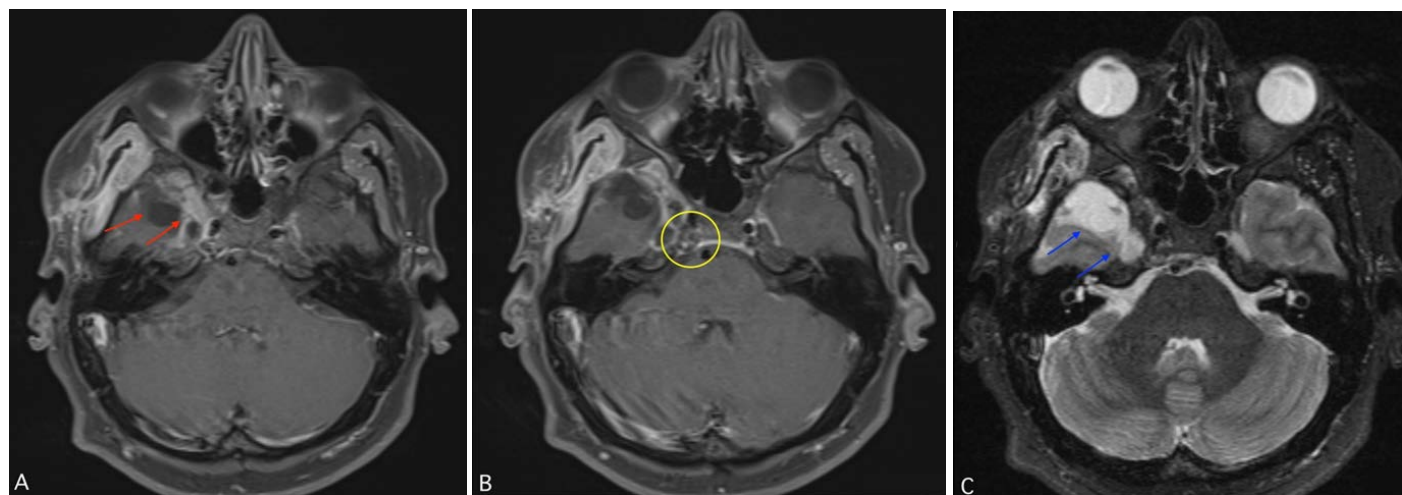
Postoperative MRI of the skull base. Axial T1 postcontrast (A, B) and axial T2 (C) images demonstrate postoperative changes of interval right pterional craniotomy for resection of the skull base chondrosarcoma. Lobulated area of homogenous enhancement within the medial floor of the right middle cranial fossa along the previously resected right sphenoid wing felt to represent postoperative changes (A) with corresponding T2 hyperintensity (blue arrows). Within the posterior aspect of the right petroclival junction (yellow circle), there is a focus of heterogeneous enhancement, which could reflect residual tumor versus treatment changes.
